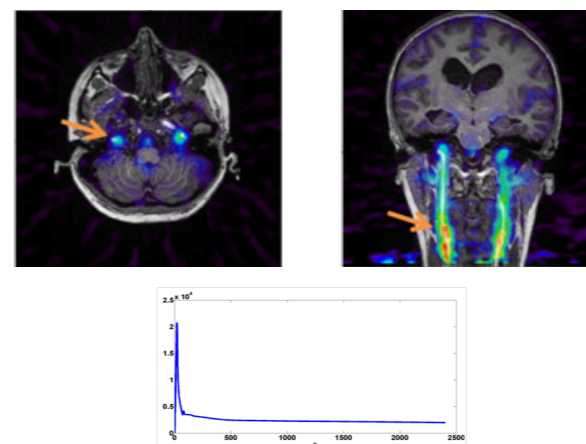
Image derived input function obtained from a manually drawn carotid region in the PET overlaid with the MR image (MPRAGE high contrast).
